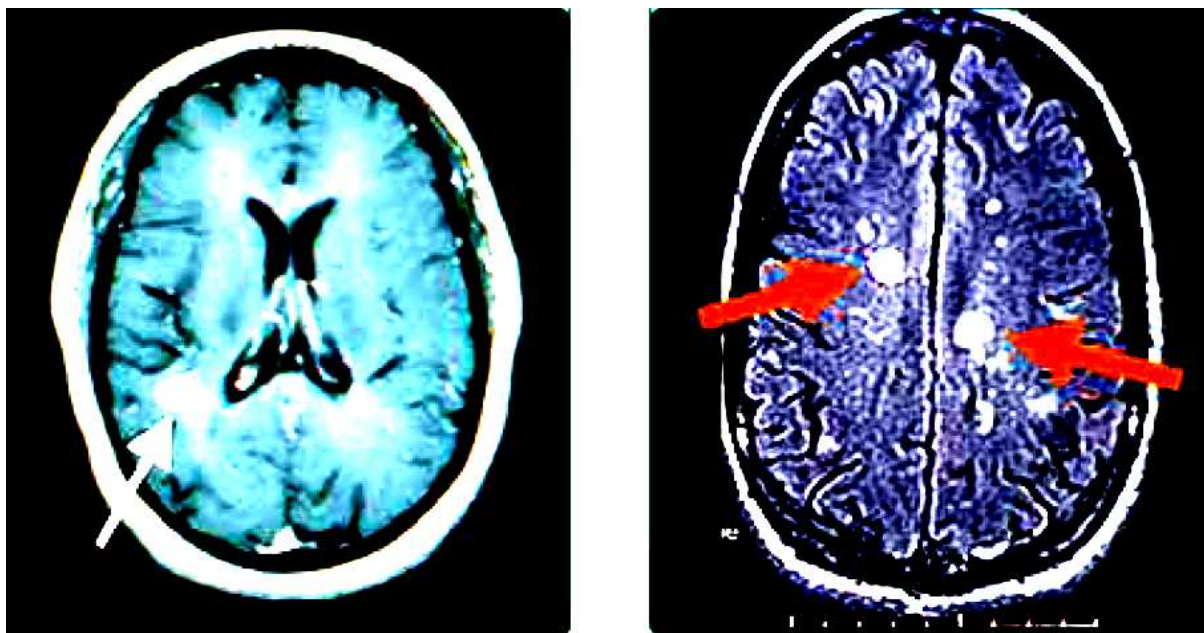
Magnetic Resonance Imaging of damaged MS brains.
